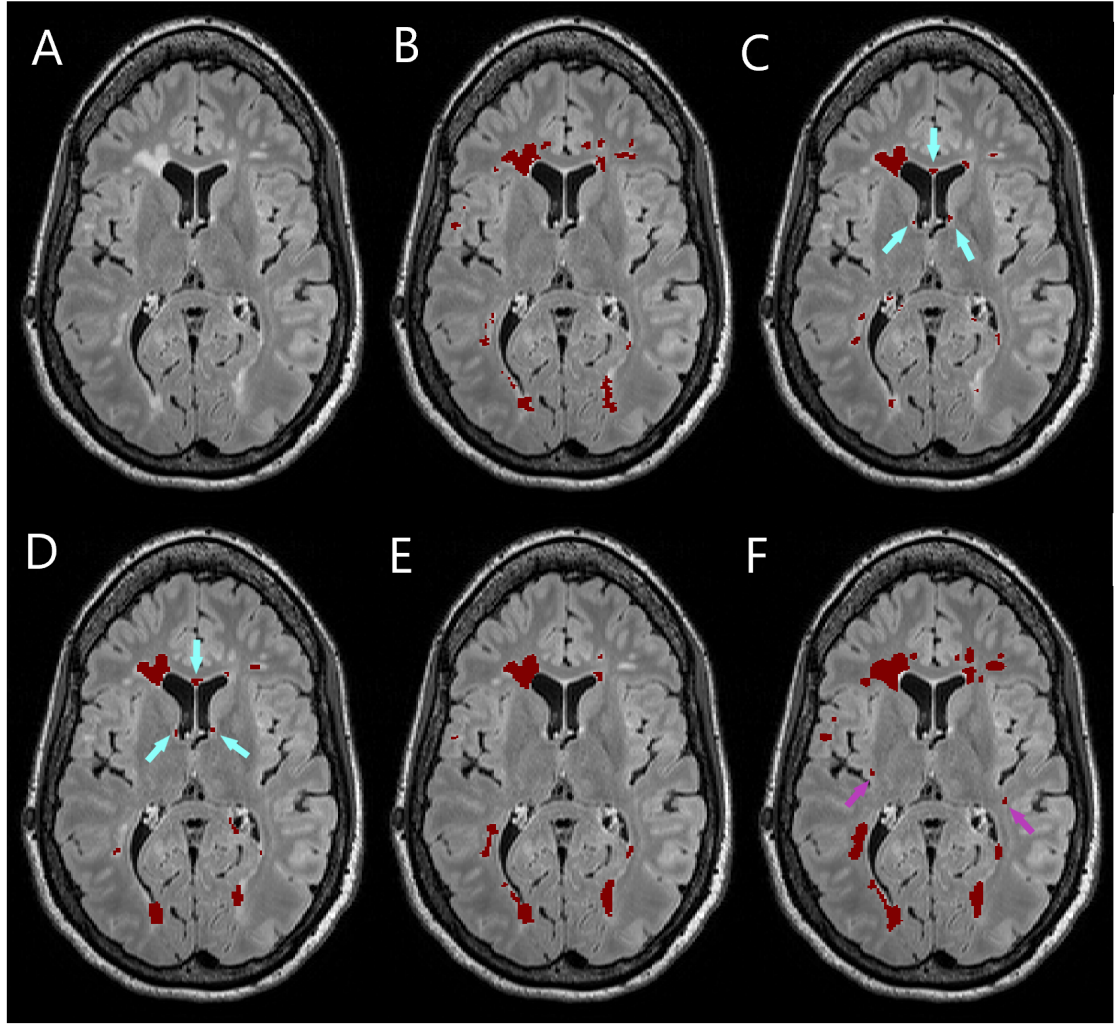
Example segmentations of a case from the Insel32 dataset, axial view. (A) FLAIR image, plus segmentations from (B) manual raters, (C) LPA, (D) LGA, (E) Nabla-net and (F) DeepSCAN (multi-task). Segmentations from LGA and LPA show erroneous segmentation of healthy-appearing tissue near the ventricles (cyan arrows). DeepSCAN identified two subtle lesions (violet arrows) missed by the manual raters but subsequently confirmed by our experienced neuroradiologists.
